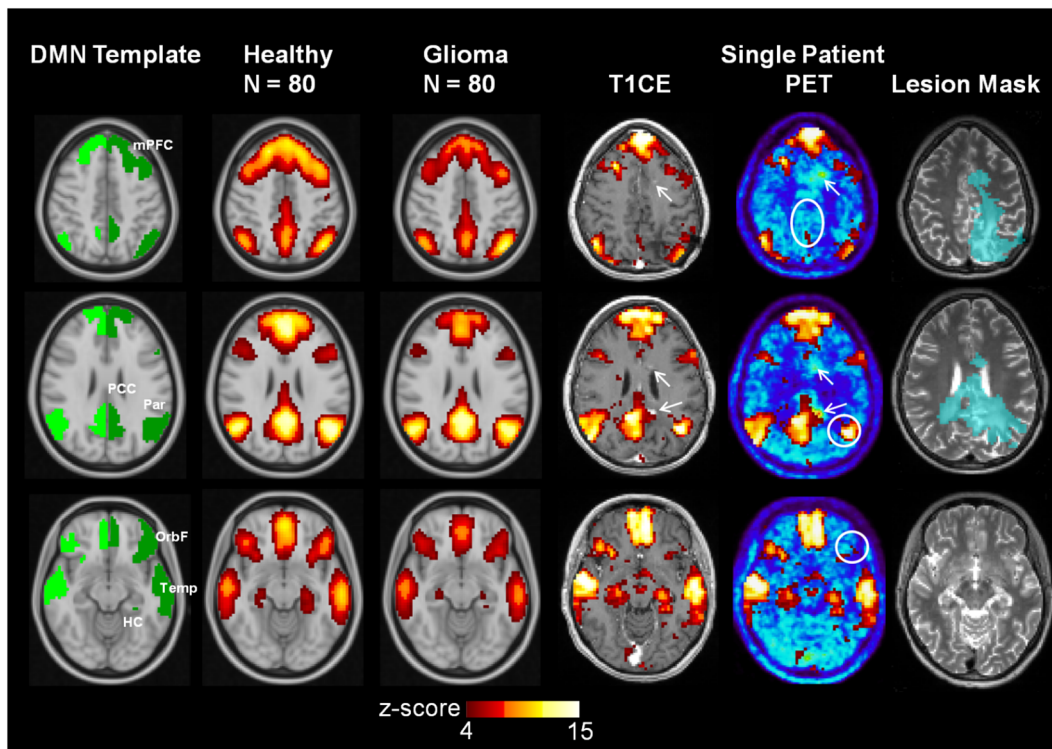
Default Mode Network (DMN) template and average DMN (z-score map) in 80 post-therapeutic glioma patients and a matched cohort of healthy subjects. The individual DMN network of a female patient with a small, multifocal recurrence with perifocal edema 10 months after first-line therapy is shown on the right. The circles in white depict the DMN-nodes with reduced connectivity. T1CE: T1-weighted MR image with contrast enhancement, PET: O-(2-[18 F]fluoroethyl)-L-tyrosine Positron-Emission-Tomography, arrows: multifocal, small contrast-enhancing, PET-positive tumor nodules. DMN nodes: mPFC - medial prefrontal cortex, OrbF - orbitofrontal cortex, PCC - posterior cingulate/retrosplenial cortex, Temp - lateral temporal cortex, Par - inferior parietal lobule, HC - hippocampus/parahippocampal cortex.
